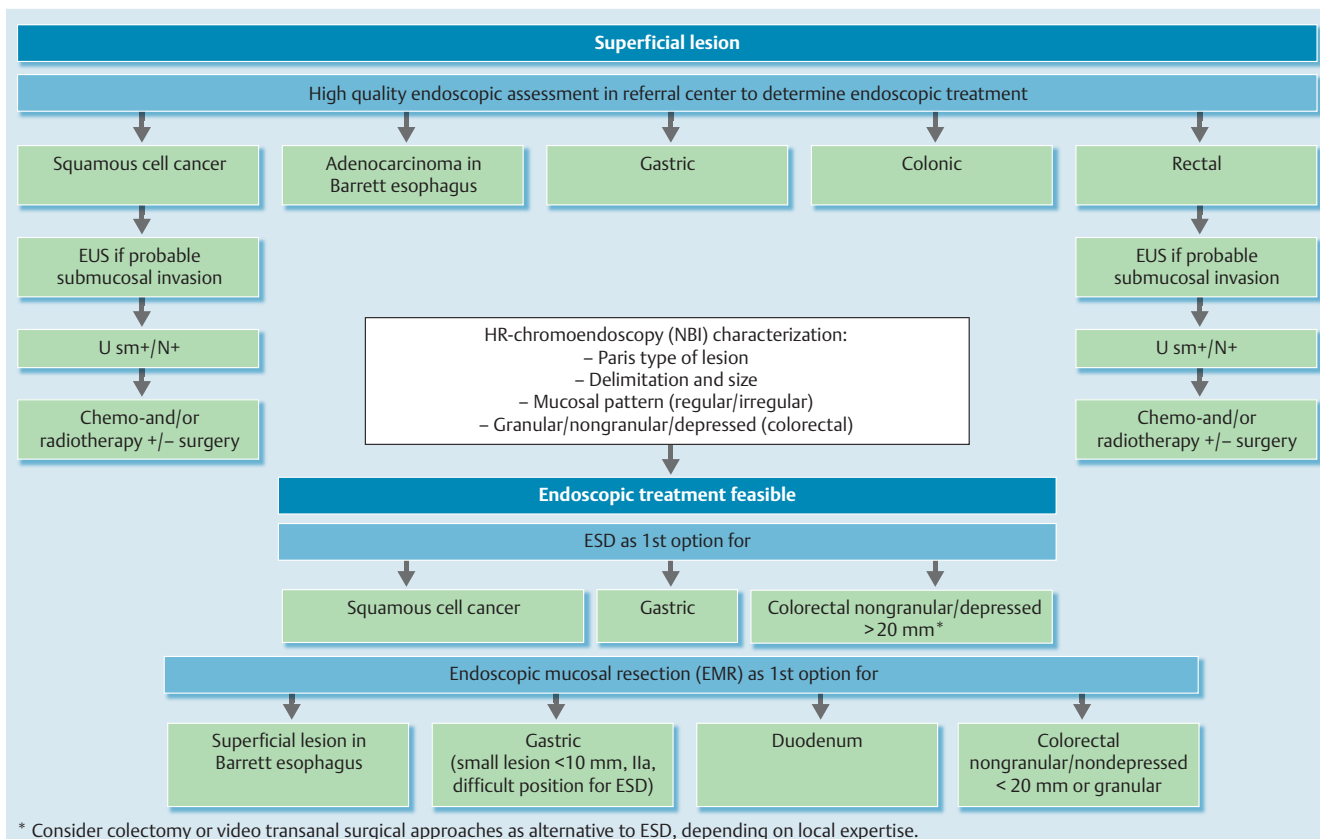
Endoscopic submucosal dissection (ESD) for superficial lesions: a decision-making algorithm. EUS, endoscopic ultrasound; U sm+/N+, ultrasound suggestive of submucosal invasion or positive lymph nodes.
